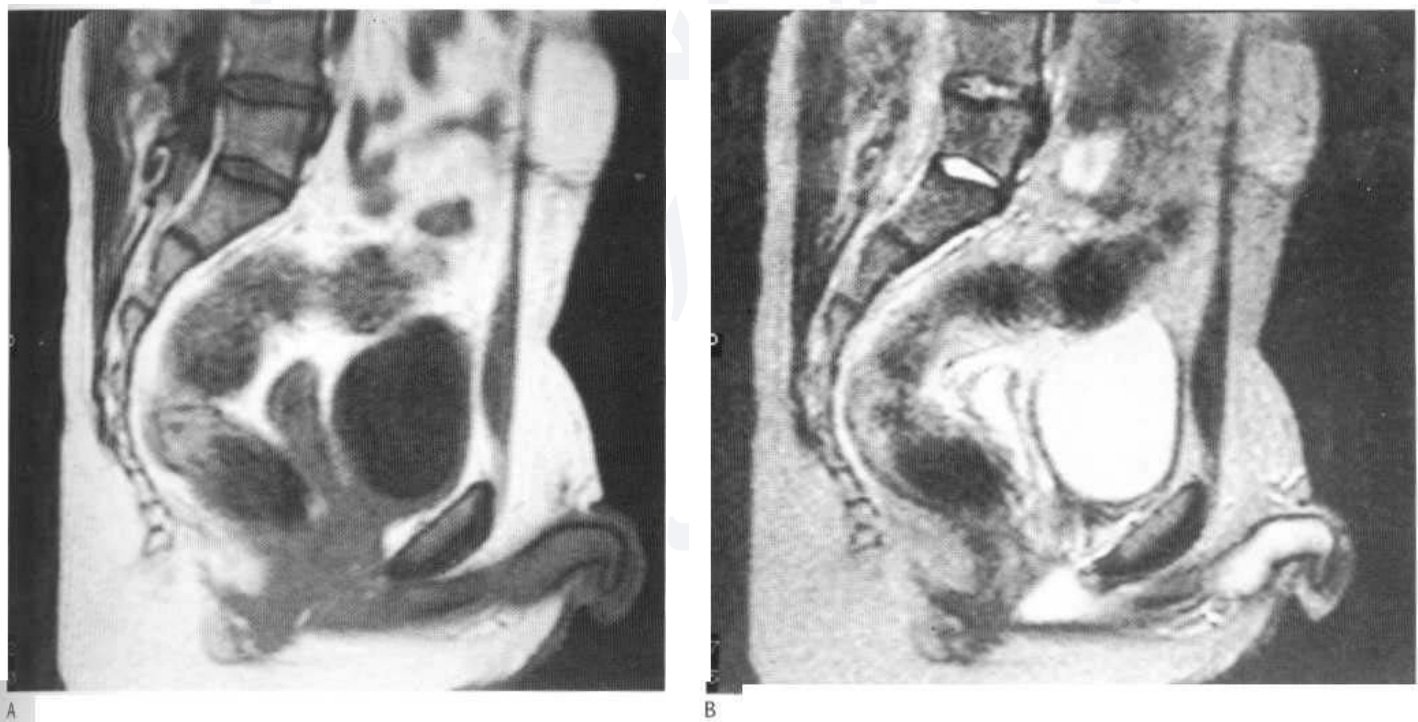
Sagittal T₁-weighted (A) and T₂-weighted (B) MR images in a patient with Nunan's syndrome showing male external genitalia and a uterus.
